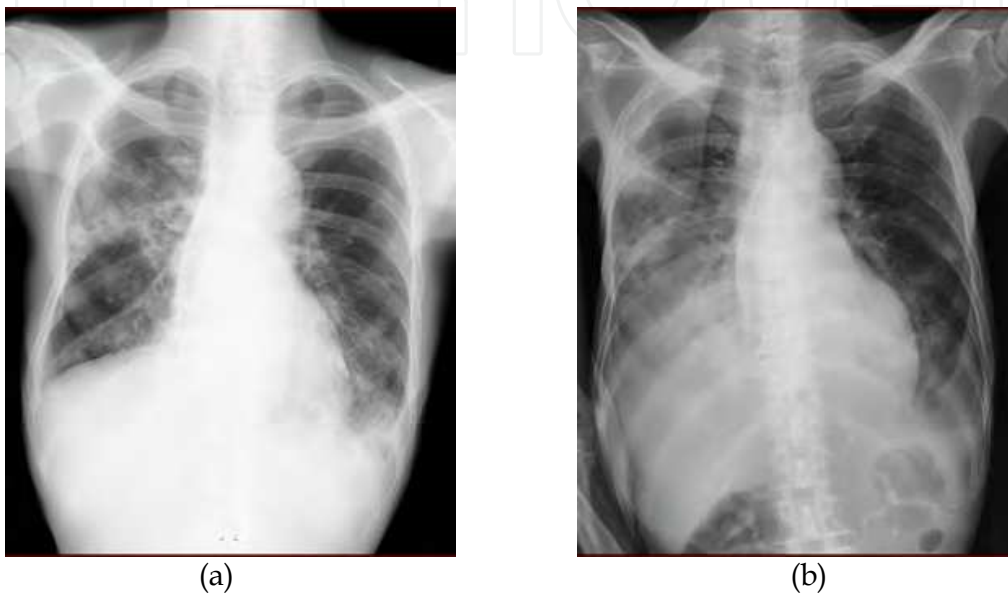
Chest X-rays in case 2. On admission consolidation was detected in the right lung (a). Consolidation shadows and pleural effusion were detected in the right lung on the sixth hospital days (spine position) (b).
